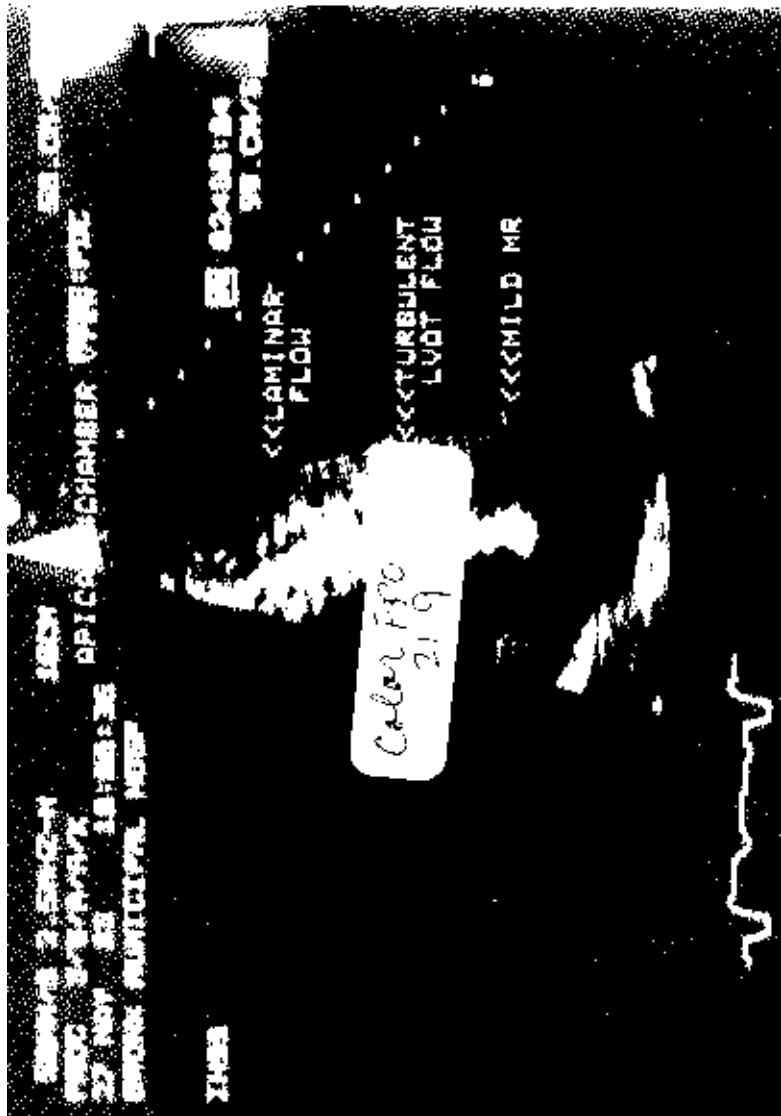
Color Doppler flow display from a patient with obstructive hypertrophic cardiomyopathy shows turbulent flow in the LVOT and mild mitral regurgitation (MR).
